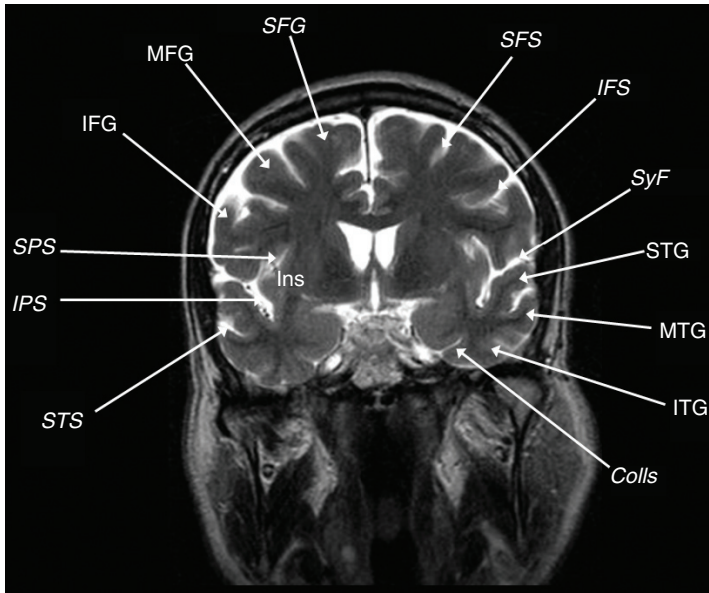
Coronal T2-weighted MRI scan showing the superior frontal gyrus (SFG), middle frontal gyrus (MFG), inferior frontal gyrus (IFG), superior peri-insular sulcus (SPS), inferior peri-insular sulcus (IPS), superior frontal sulcus (SFS), inferior frontal sulcus (IFS), sylvian fissure (SyF), superior temporal gyrus (STG), superior temporal sulcus (STS), middle temporal gyrus (MTG), inferior temporal gyrus (ITG), and collateral sulcus (Colls).
